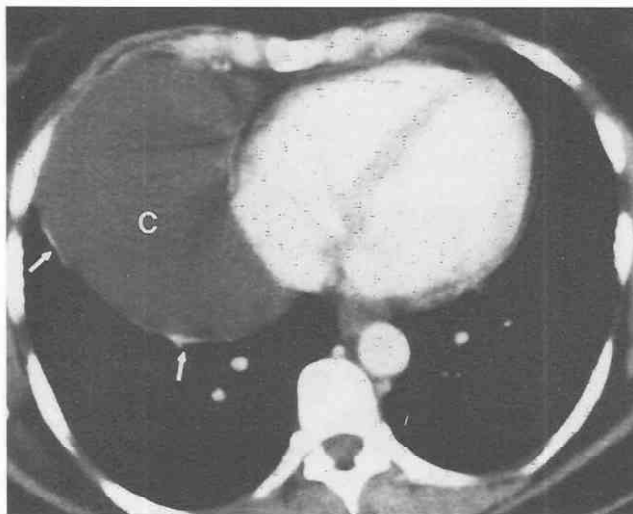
Pericardial cyst. Contrast-enhanced CT shows a large, homogeneous, water-attenuation mass (C) in the right cardiophrenic angle. The wall is imperceptible; enhancement at the periphery (arrows) is caused by atelectatic lung. The location and appearance are typical for pericardial cyst.
